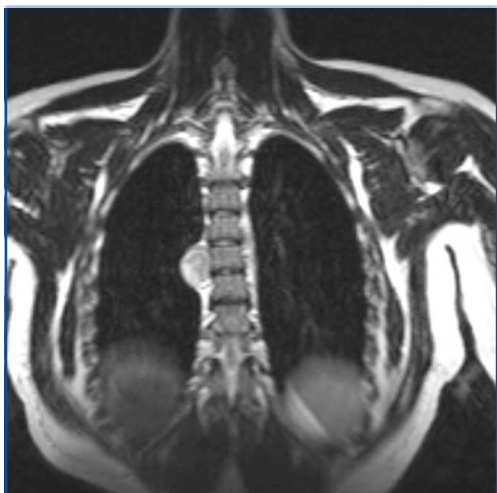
Coronal T2-weighted magnetic resonance imaging sequence showing a large right-sided paraspinal lesion at the T6 level.
